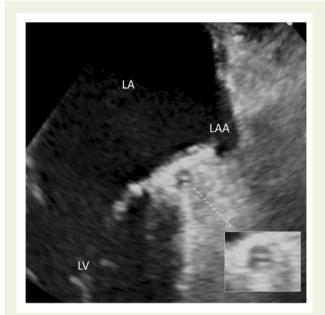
Modified mid-oesophageal transoesophageal echocardiography view (bi-commissural view; transducer angle: $\sim 60^{\circ}$) showing a flap in the left coronary artery similar to that one observed in the ascending aorta (Supplementary material online, *Video S2*). LA, left atrium; LAA, left atrial appendage; LV, left ventricle.
